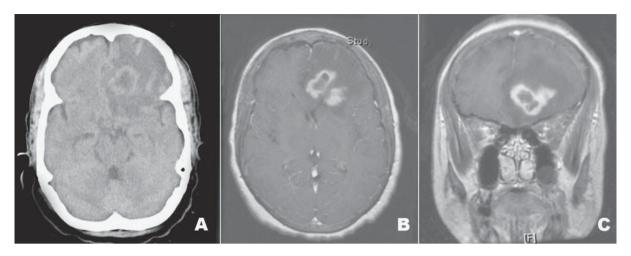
Brain imaging on initial presentation: (A) Non-contrast CT image with left frontal lobe lesion with surrounding edema. (B, C) Axial and coronal MRI images demonstrating a ring-enhancing mass lesion associated with extensive vasogenic edema.
